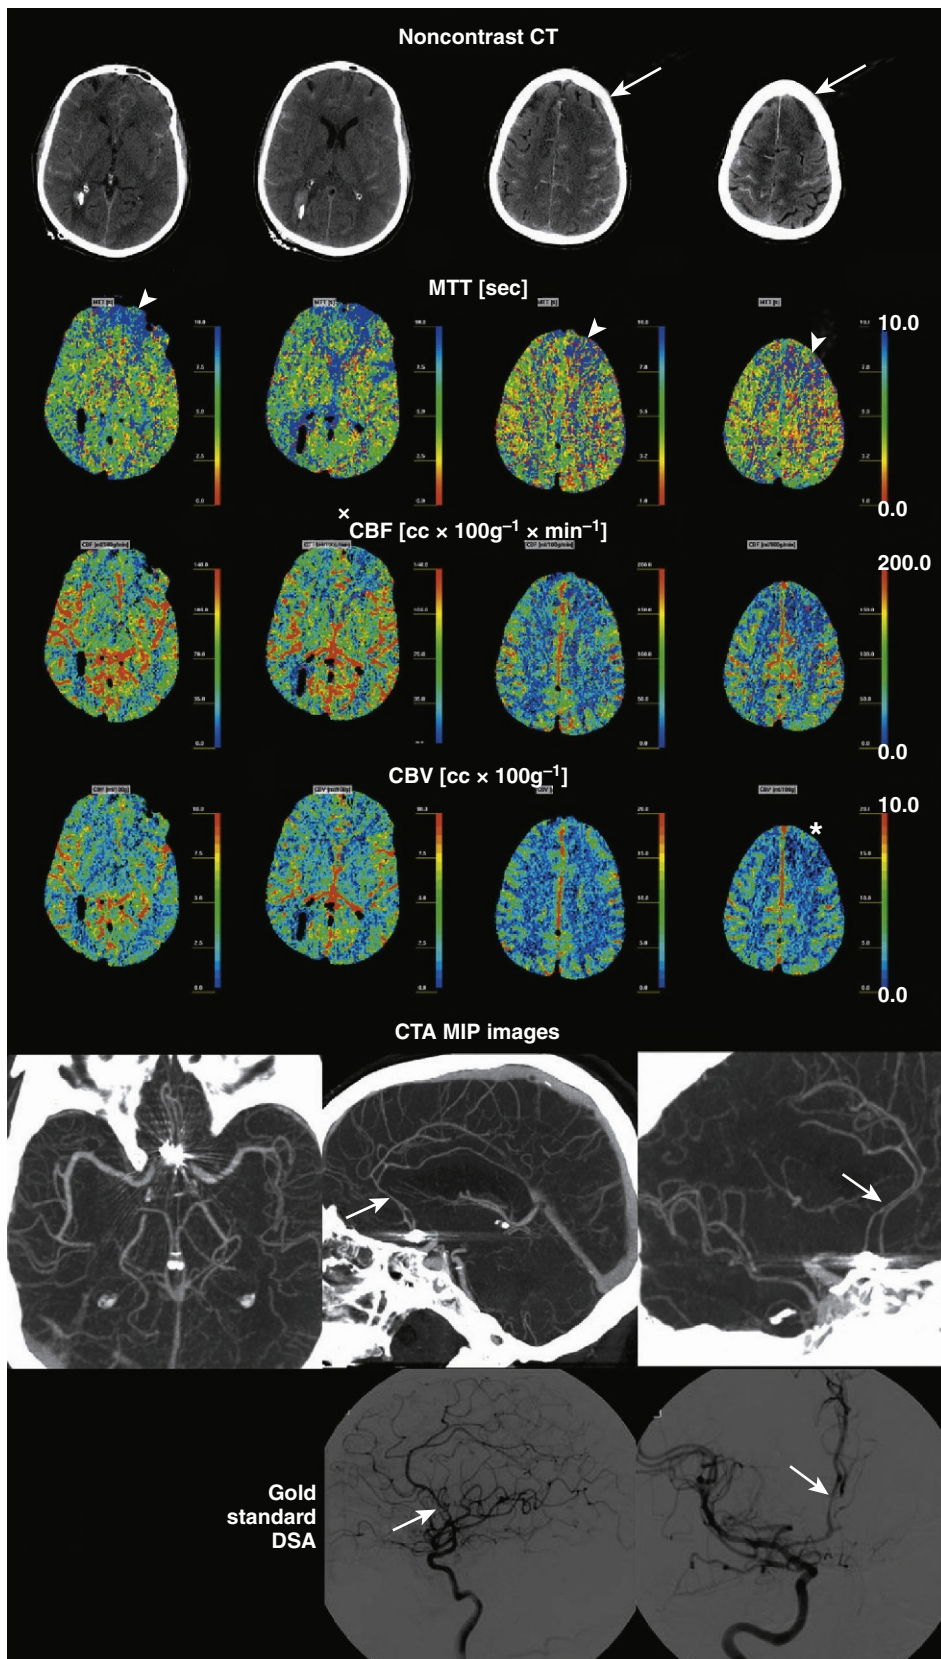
Patient transferred at day 8 to neurovascular intensive care unit (ICU) from an outside institution after coiling of a ruptured anterior communicating artery aneurysm. Unenhanced brain computed tomography (CT) obtained at the admission of the patient in our neurovascular ICU demonstrated extensive residual subarachnoid hemorrhage and suspicious loss of gray–white matter contrast in the left superior frontal gyrus (white arrows). The tip of a right ventricular drain catheter is also visible.
